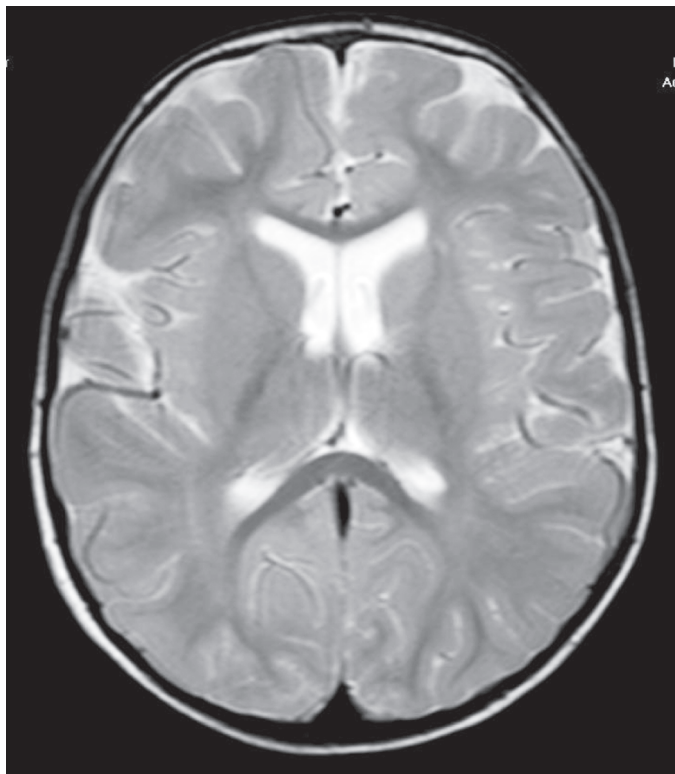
T2W axial MRI at the level of the basal ganglia shows no signal changes in the globus pallidus or in the areas of white matter calcification seen on the CT sections.
